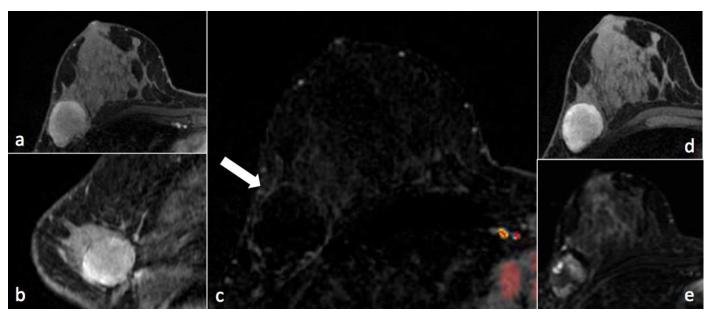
29 year-old female with metaplastic breast carcinoma. FINDINGS: Post chemotherapy MRI demonstrates a right breast T1 hyperintense, STIR heterogeneously hyperintense mass with interval decrease in size to 3.0 cm, and no detectable enhancement (white arrow in Figure 6c). TECHNIQUE a) axial T1 fat-saturated post-contrast image, 1.5T MRI, 1.6mm slice thickness, TR 5.5, TE 2.6, 15ml IV omniscan at 90 seconds post contrast administration b) sagittal reformatted T1 fat-saturated post-contrast image, 1.5T MRI, 0.74mm slice thickness, TR 5.5, TE 2.6 c) axial T1 subtraction with overlying angiomap, T1 fat-saturated 90 second post-contrast administration axial image subtracted by T1 fat-saturated pre-contrast administration axial image, 1.5T MRI, 1.6mm slice thickness, superimposed with kinetics angiomap of red-Type III rapid washout kinetics, yellow - Type II rapid plateau kinetics, blue - Type I rapid persistent kinetics. d) axial T1 fat-saturated pre-contrast image, 1.5T MRI 1.6mm slice thickness, TR 5.5, TE 2.6 e) axial Short tau inversion recovery (STIR) image, 1.5T MRI, 3.2mm slice thickness, TR 3000, TE 66.7
